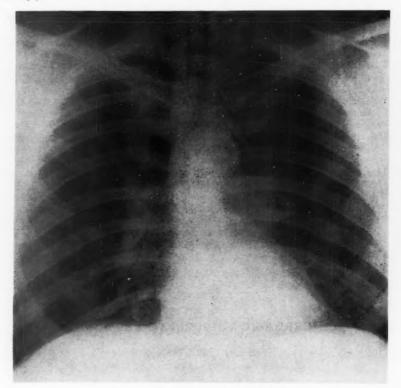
Chest x-ray, February 10, 1957.
